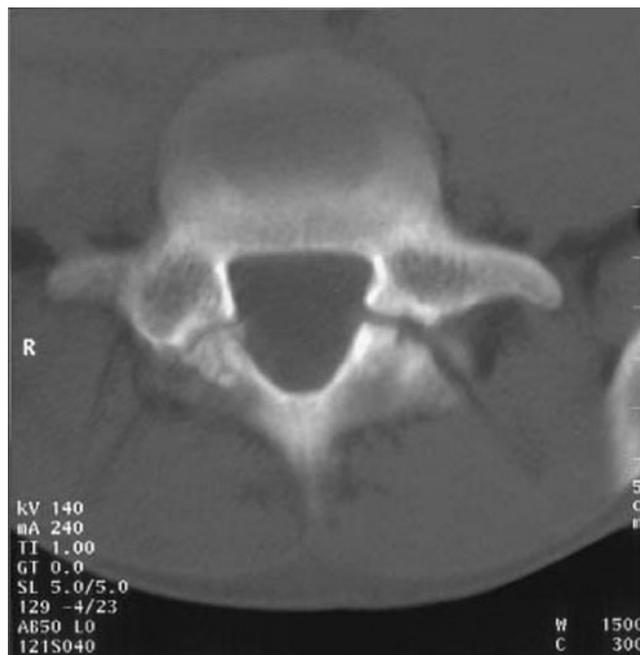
CT image of lumbar spine showing bilateral spondylolysis at the L5–S1 level.
